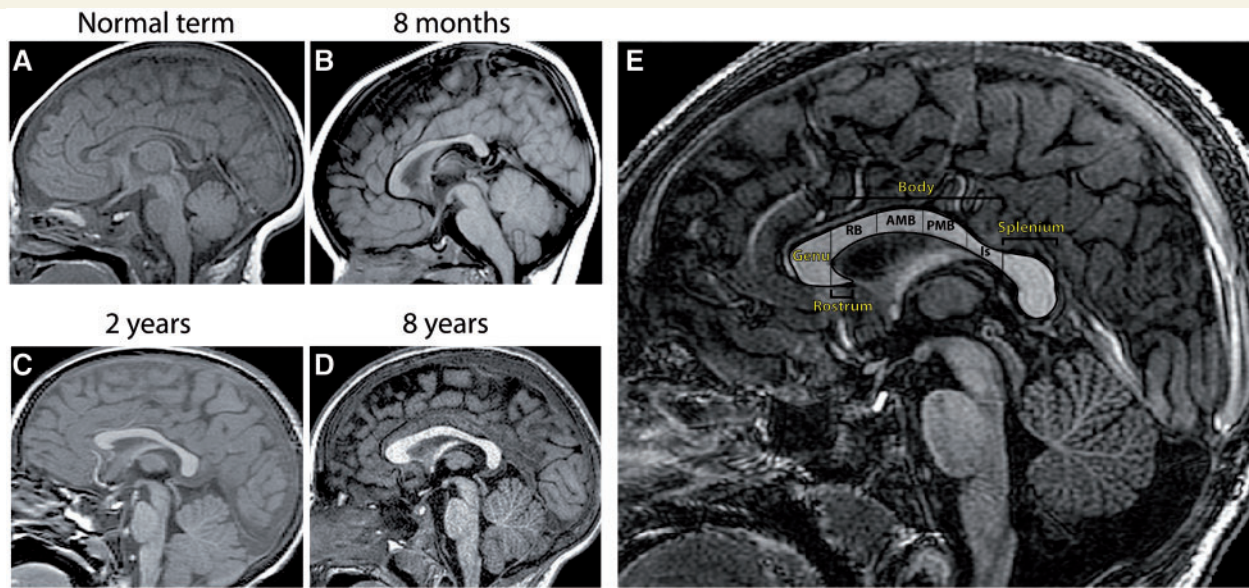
T₁-weighted sagittal MRI scans showing the structure of the normal human corpus callosum in the full-term infant (A), 8-month-old (B), 2-year-old (C), 8-year-old (D) and adult (E). (A) At birth, the corpus callosum has assumed its general shape but is thinner throughout. The thickness of the corpus callosum (vertical dimension) increases generally throughout childhood and adolescence. Growth in the anterior sections is most pronounced within the first 10 years of life (compare C with D), and posterior growth predominates during adolescence (compare D with E). There is also marked interindividual variation in corpus callosum size and shape. (E) Normal adult corpus callosum, showing subdivisions established by Witelson (1989). The corpus callosum is initially divided into genu, rostrum, body and splenium. The body can be further subdivided into the isthmus, and the anterior, middle and posterior segments. RB = rostral body; AMB = anterior midbody; PMB = posterior midbody; Is = isthmus.
